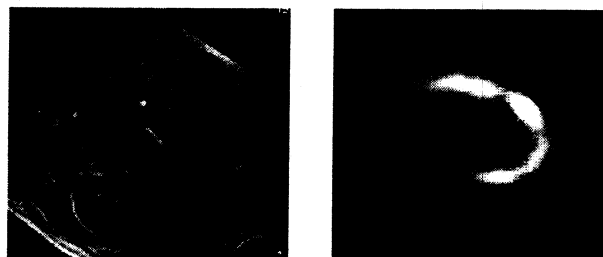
An example of starting images: long axis views of MRI (left) and SPECT (right) images.
